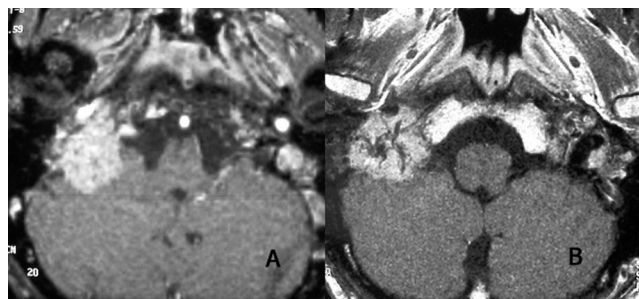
(A and B) Magnetic resonance image after Gd showing encasement and stenosis of the distal cervical portion of the internal carotid artery.
